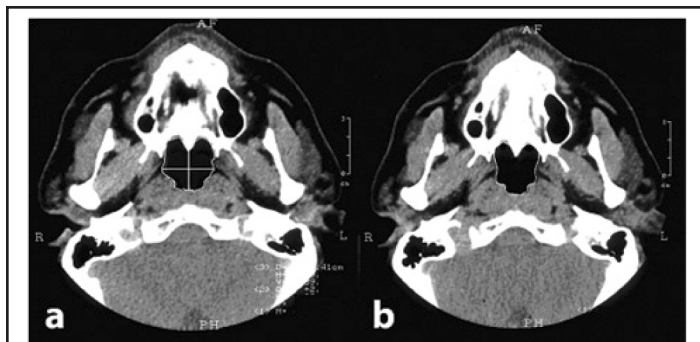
Preoperative computed tomographic scan of the high retropalatal area with the tracings for measuring its cross-sectional area and sagittal and transverse diameters. (a) tidal breathing. (b) Muller maneuver.
